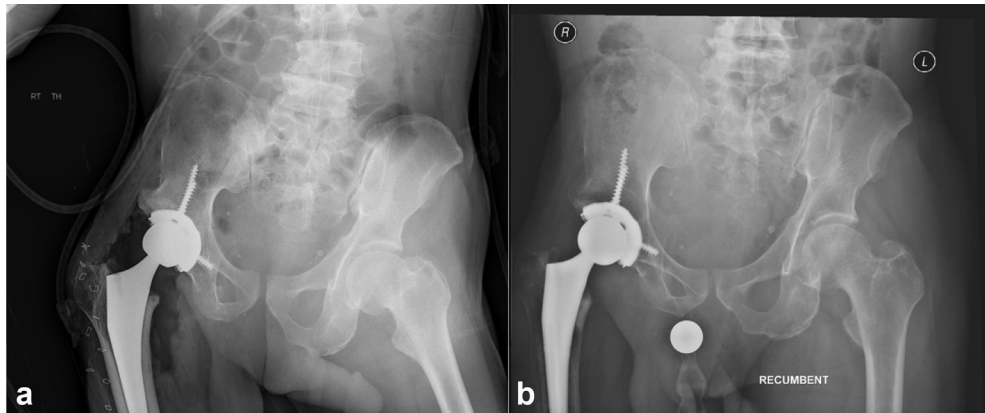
(a) Postoperative radiographs demonstrate acceptable position and alignment of uncemented total hip arthroplasty. (b) One-year postoperative radiographs demonstrate osteointegration without evidence of mechanical loosening.
